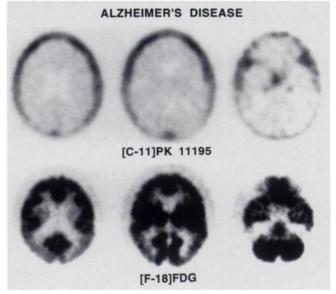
Selected slices of [11C]PK 11195 and [18F]FDG studies in a subject with moderate Alzheimer's disease. The activity in the midline in the third [11C]PK 11195 image is physiologic uptake within the paranasal sinuses.
